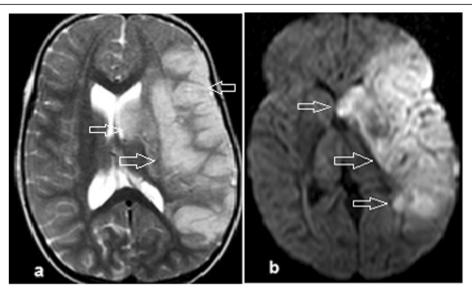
MRI demonstrates, multiple recent (acute) infarctions seen at the entire left MCA territory including the left frontal and parietal region as well as left caudate and lentiform nuclei with mild mass effect over the ipsilateral lateral ventricle and mild midline shift to the opposite site, eliciting bright T2W (a) and diffusion restriction (b)
